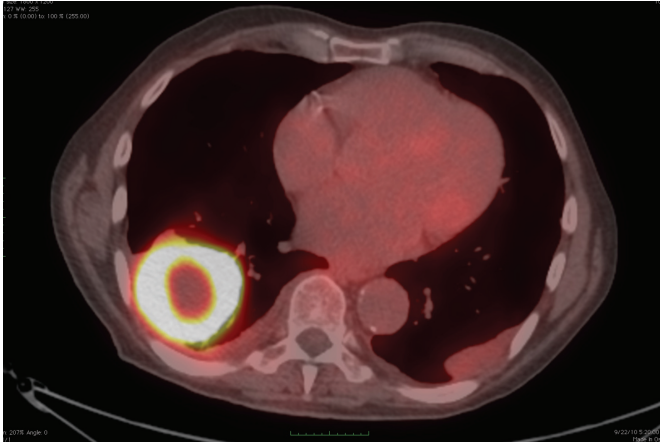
Hybrid fluoro-deoxyglucose (FDG) positron emission tomography/computed tomography image showing a thick-walled mass characterized by FDG uptake with a maximum standardized uptake value of 15.9 in the wall of the mass and central photopenia, consistent with cavitation and central necrosis.
